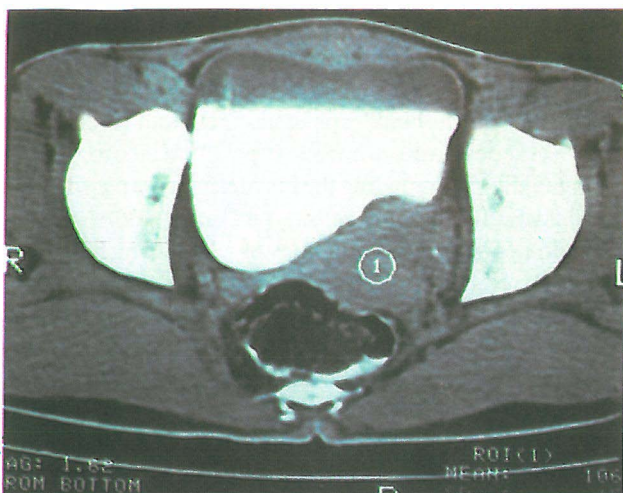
Patient's CT scan showing the mass effect of the tumor on the bladder wall.
